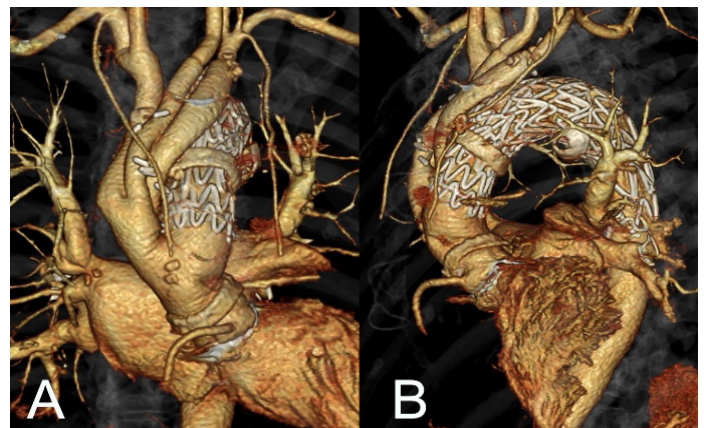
(A, B) Postoperative three-dimensional computed tomography showing reconstruction of the supra-aortic vessels with a Lupiae vascular prosthesis and aortic stent grafts.
